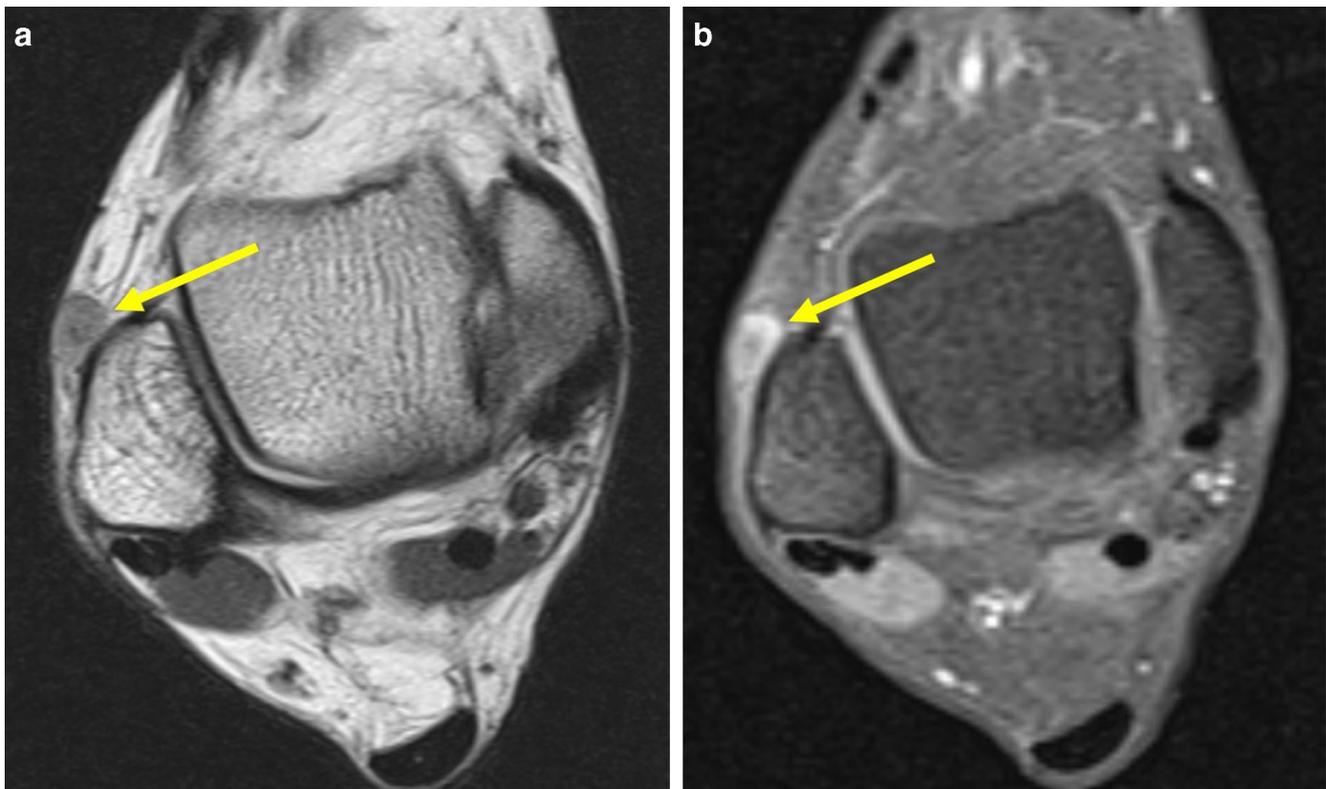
A 58-year-old woman with a painful ankle mass. a Axial proton density-weighted MRI depicts a 0.8-cm subcutaneous nodule over the lateral malleolus (*arrow*); there is no discernable internal fat signal. b
